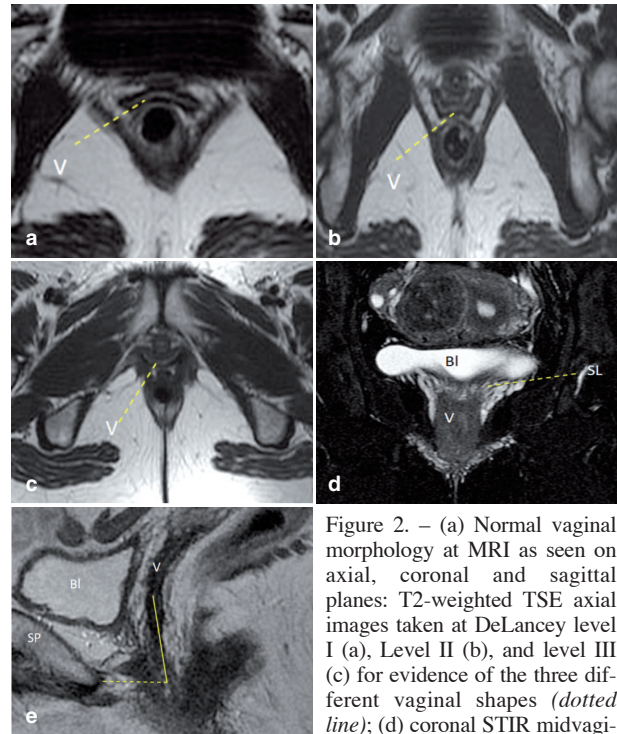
(a) Normal vaginal morphology at MRI as seen on axial, coronal and sagittal planes: T2-weighted TSE axial images taken at DeLancey level I (a), Level II (b), and level III (c) for evidence of the three different vaginal shapes (dotted line); (d) coronal STIR midvaginal image showing the vaginal apex and the site at which the suspensory vaginal support structures converge on both sides (dotted line); (e) sagittal T2 weighted TSE image showing the paracolpium as an hyperintense structure beyond the anterior and posterior vaginal walls. A vaginal angle of 72 degrees is formed by the intersection of the reference line (dotted line) with the distal vaginal axis (continuous line). V= vagina; BL= bladder; SL= suspensory ligaments; SP= symphysis pubis.
